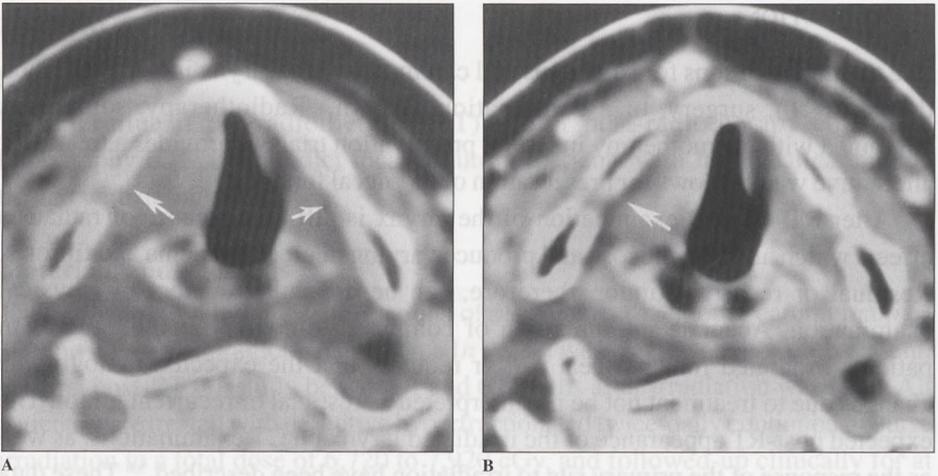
CT images of a patient with a T3 carcinoma of the right true vocal cord and a low pretreatment risk profile. (A) Pretreatment CT image at the true cord level shows involvement of the entire right cord, which is a paramedian position. The ipsilateral paraglottic space is obliterated (large arrow), when compared to the contralateral side (small arrow). (B) CT image obtained 4 months post-RT at the same level. There is complete resolution of the tumor. The laryngeal tissues appear symmetric, and the paraglottic space on the right side has reappeared (arrow); post-RT CT-score 1. The patient is without evidence of disease 31 months after completion of radiotherapy. Figure 1A, reprinted with permission.¹⁰
